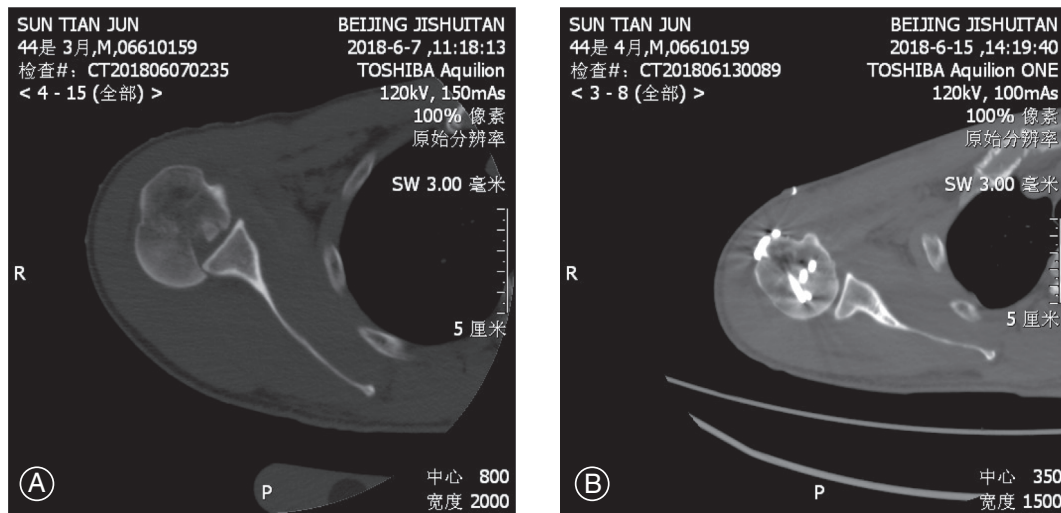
CT images of reverse Hill–Sachs lesion. (A) Preoperative image showed locked posterior shoulder dislocation; (B) 8 weeks postoperative image showed fracture healing.
